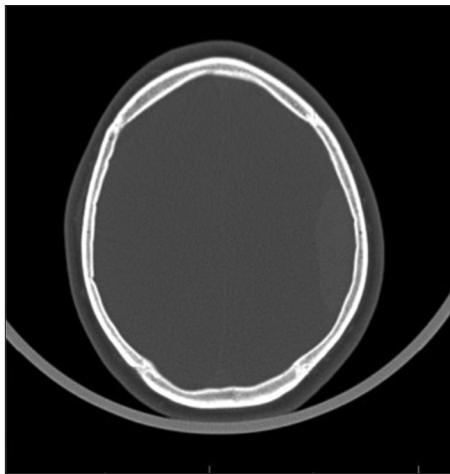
Notably, the bone window CT demonstrated no accompanying skull fracture.
